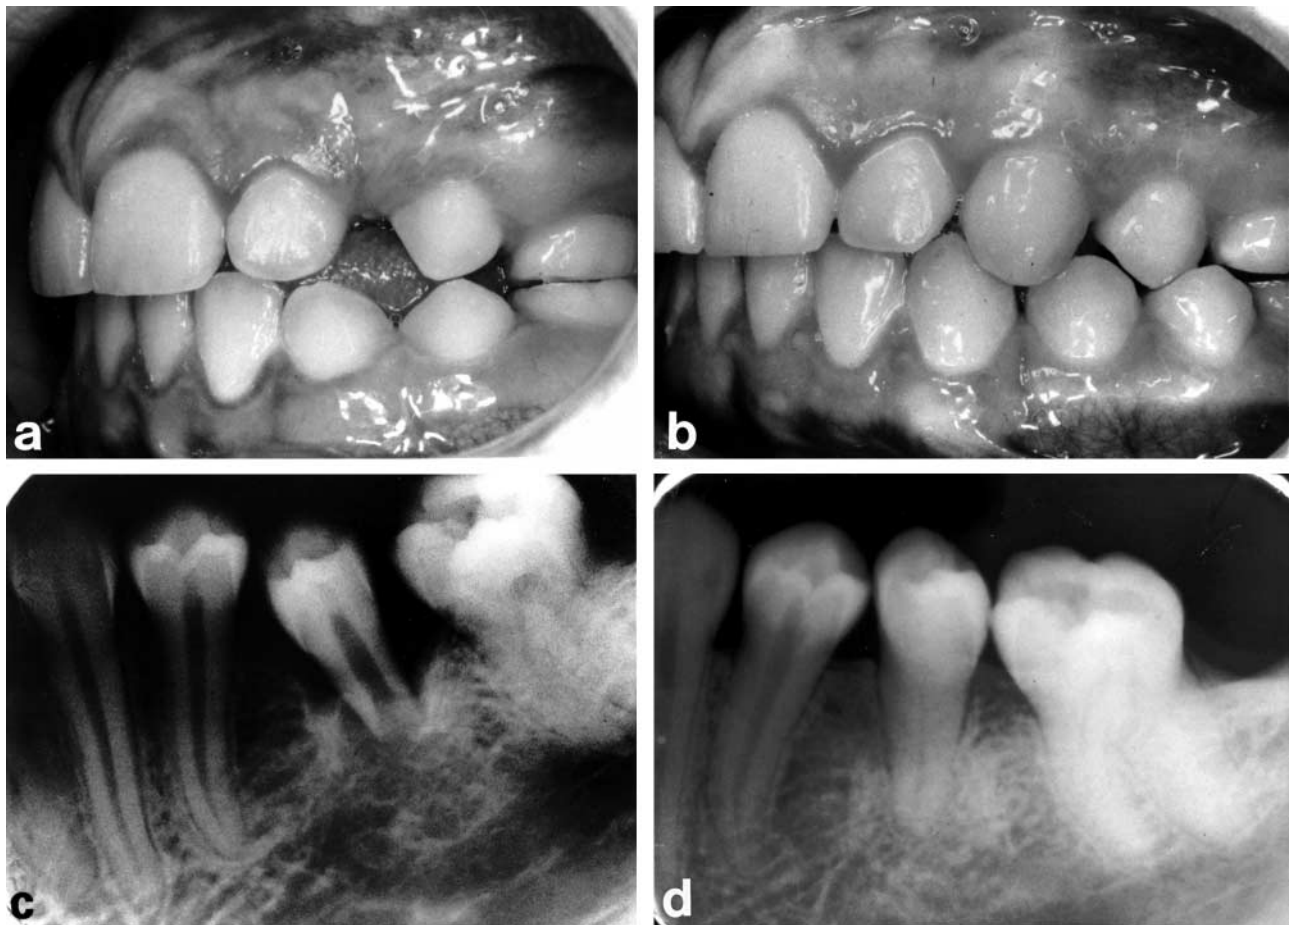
(a) A 10-year-old boy with agenesis of lower left second premolar and lower left second molar. Space deficiency in the upper jaw. (b) Maxillary left second premolar transplanted to the region of lower left second premolar. (c) X-ray at the time of transplantation. (d) X-ray 4 years after transplantation.
